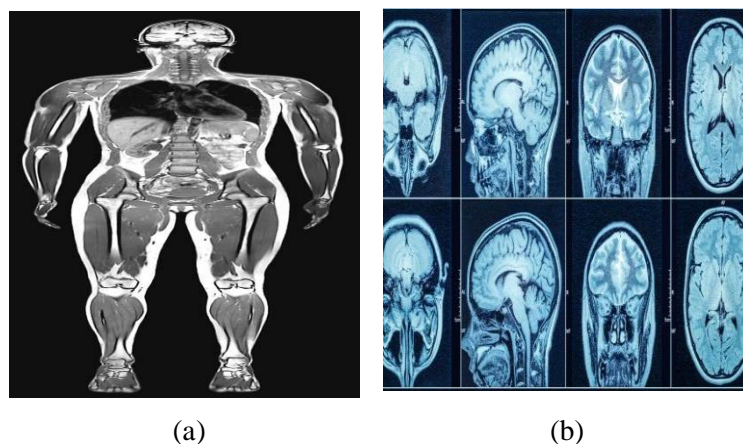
Magnetic resonance imagery (MRI): a) MRI scan for the human body and b) MRI scan for the human head
